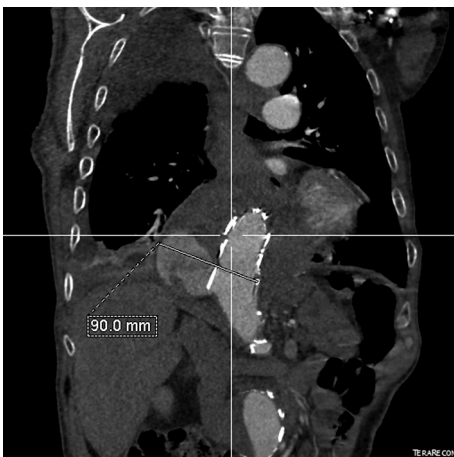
Computed tomography sagittal multiplanar reconstruction of the contained distal thoracic rupture.
